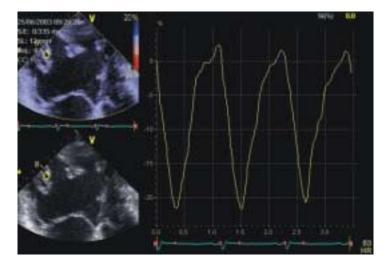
Strain analysis for evaluation of ventricular function. Apical 4 chamber view (upper left strain-coded, lower left grayscale image). Using tissue velocity imaging myocardial velocities were obtained in a systemic right ventricle of a patient with complete transposition of the great arteries and atrial switch operation. Relative longitudinal deformation, strain, can be computed in selected areas during the cardiac cycle. As the RV shortens during systole, negative strain curves are obtained (right). Strain rate, i.e. rate of deformation can also be computed from the same data-set.
